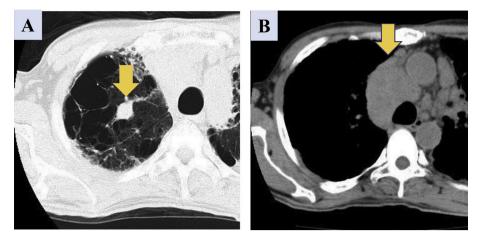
Enhanced computed tomography showed (A) a mass in the S2 site of the right lung and (B) a mass in a mediastinal lymph node.
